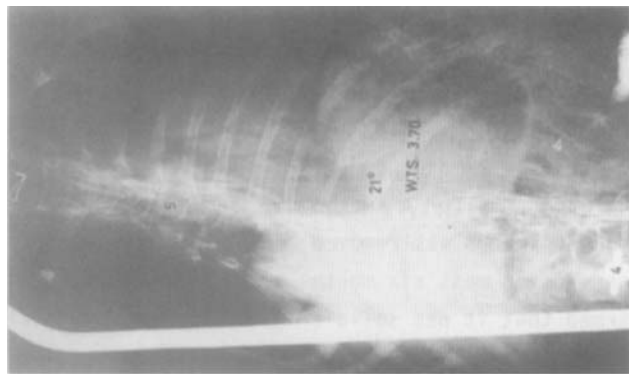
a. Antero-posterior radiograph with the patient seated. Note extent of pelvic obliquity.
